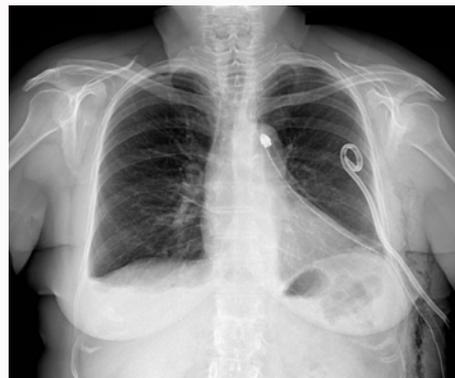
Post-operative chest X-Ray showing resolution of the pleural effusion.
